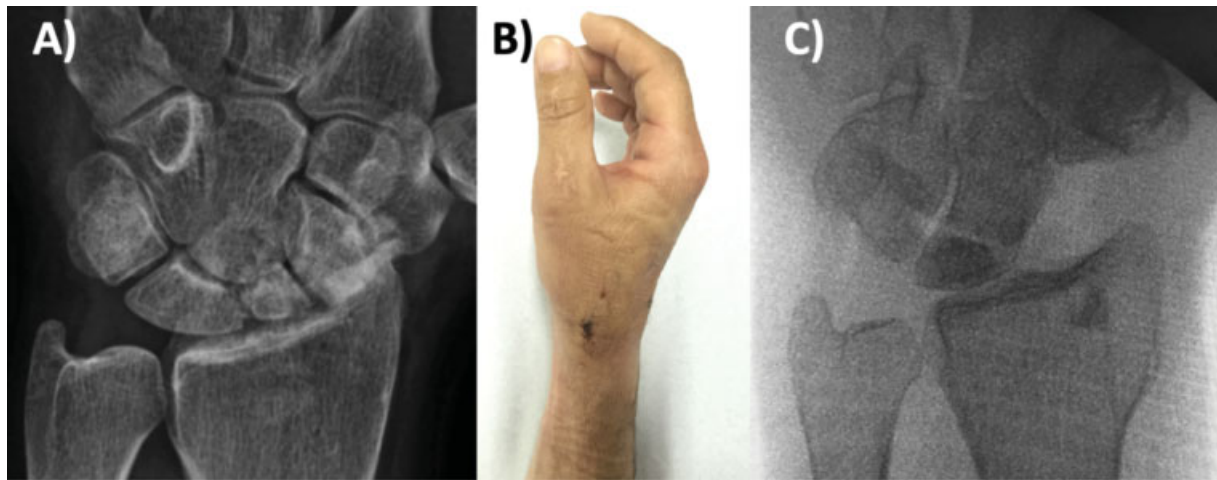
Scaphoid resection using a mini-open approach. (A) Preoperative anteroposterior (AP) wrist radiograph. (B) Lateral image of the hand and wrist of a patient submitted to the percutaneous surgery. Note the incision of the mini-open approach. (C) Intraoperative AP radioscography of the wrist showing complete scaphoid resection.
